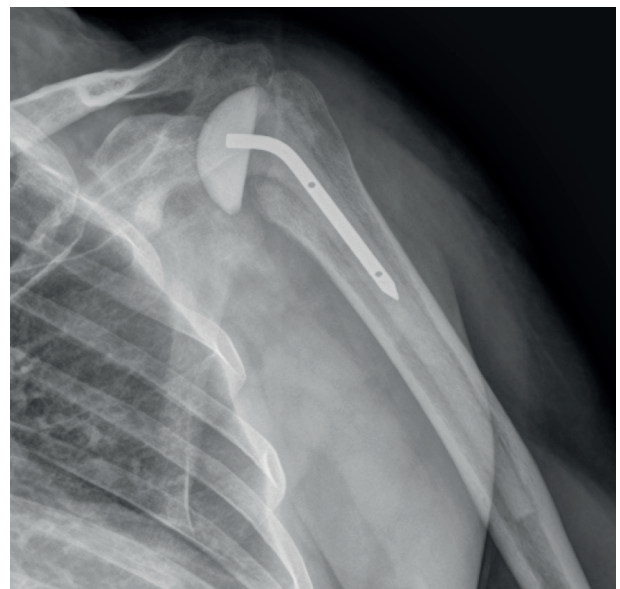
Post-operative x-rays examination after spacer positioning
